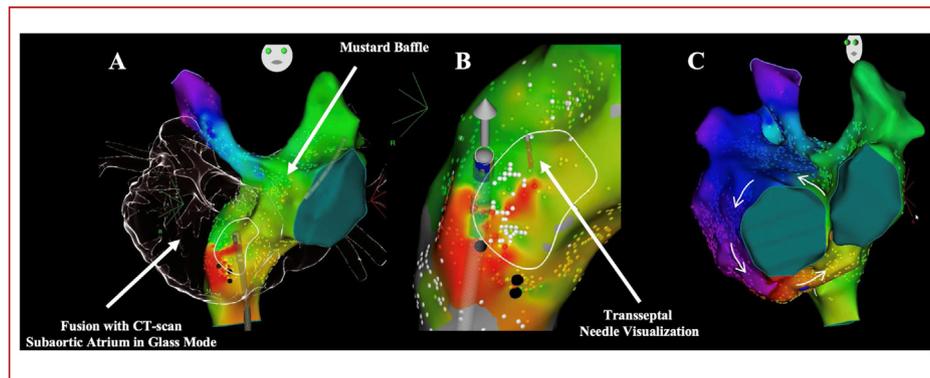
Example of a transbaffle puncture guided by three-dimensional (3D) anatomical mapping in a patient with atrial switch operation. A. 3D anatomical reconstruction of the pulmonary venous atrium and fusion with the computed tomography (CT) scan. B. The optimal site for transbaffle puncture is located and the transseptal needle is advanced and localized by the CARTO® system. C. The final activation mapping identifies an atrial flutter around the tricuspid annulus.
